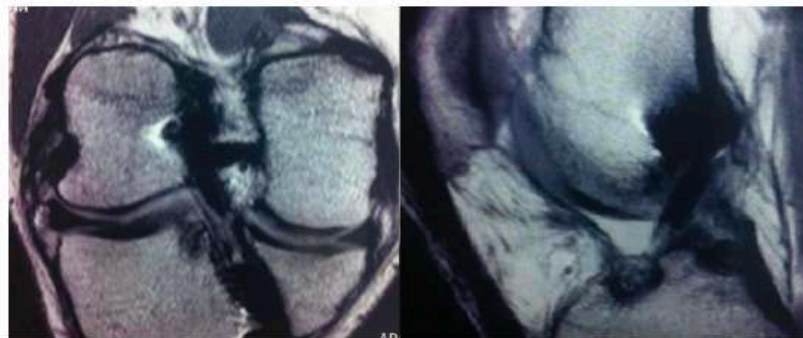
Postoperative MRI of patient 1.
